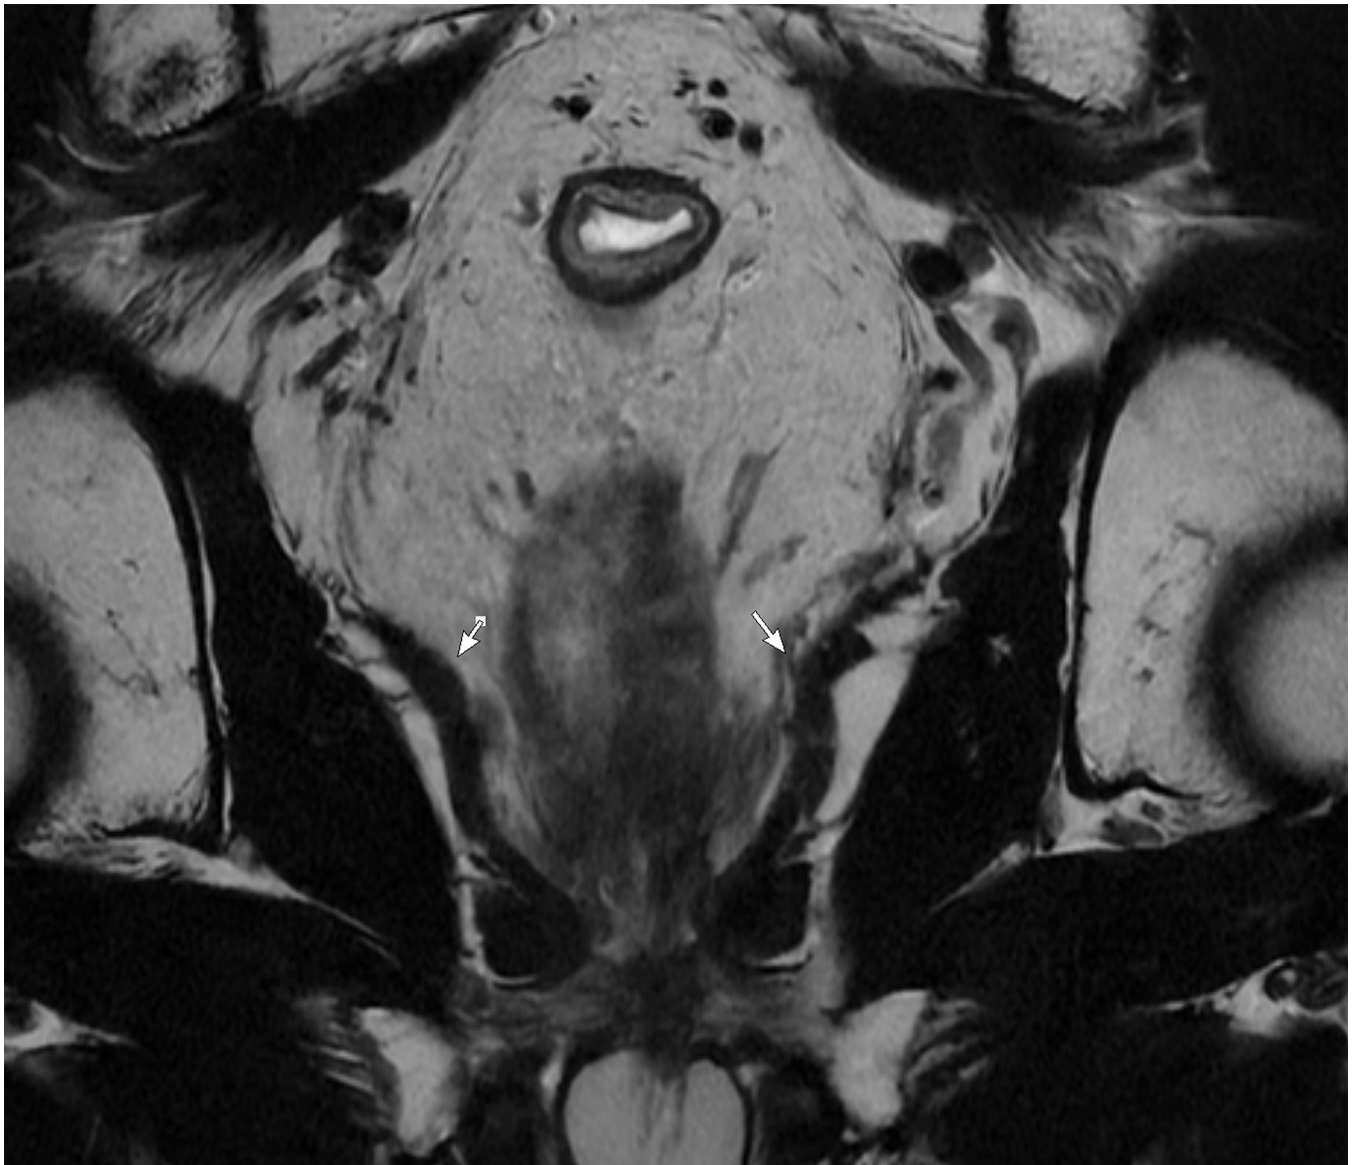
Axial (A) and (B) and Coronal (B) T2W pelvic MRI in 59-year-old male with rectal cancer after treatment. The levator ani muscles comprise the puborectalis (inner thin arrow in (A), the pubococcygeus muscle (outer thin arrow in (A), and the iliococcygeus muscle (small arrows in (C)). The anal sphincter muscles include external (black arrow (B)) and the internal (white arrow in (B)). Note the scar in the tumor bed at 6 pm in (A).
